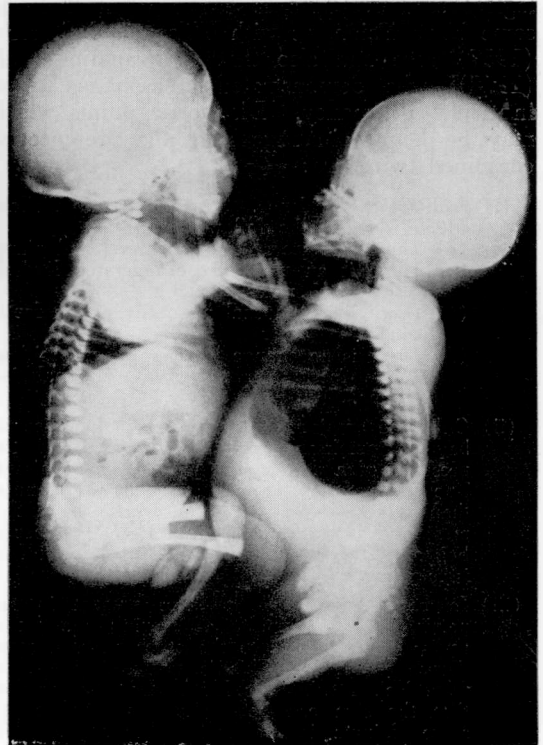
X-ray of the twins, showing the presence of gas in the bowel of the live infant. This also shows how superficial the junction appears.
